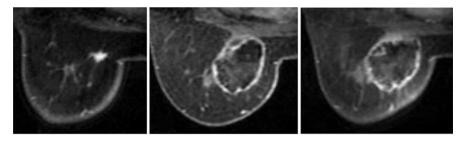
Contrast-enhanced MRI before and after. (a) Before RF ablation. (b) 6 months after RF ablation. (c) 12 months after RF ablation
